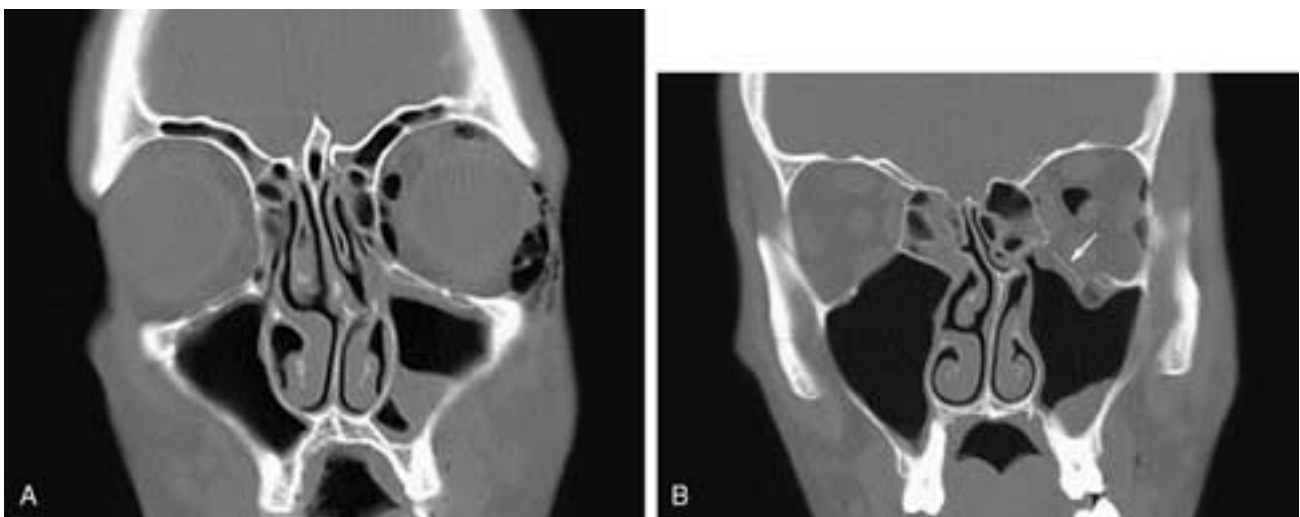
Coronal CT scans. In (A) there is an intact orbital rim anteriorly. In (B) there is an orbital floor fracture (*arrow*) in the midfloor just posterior to the orbital rim. This was a pure blow-out fracture. The fracture is just medial to the infraorbital canal, and this patient had hypesthesia in the cheek. Secretions are seen in both ethmoid sinuses, and hemorrhage occurred in the left antrum. There is also subcutaneous and orbital emphysema.
